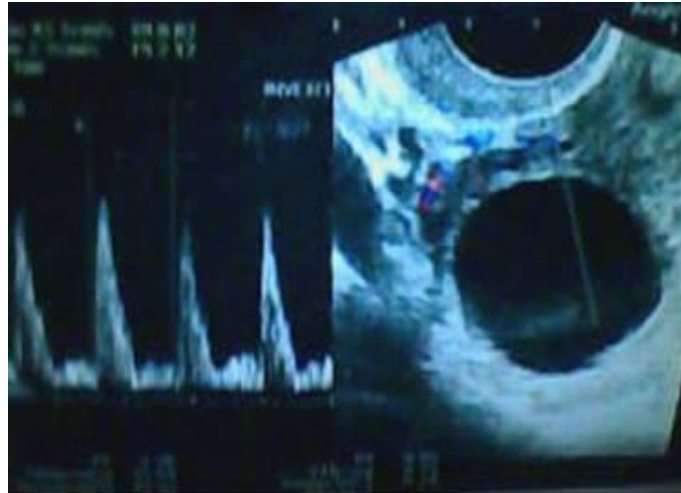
In the right ovary within the mass, flow signals were decreased in color Doppler sonography
